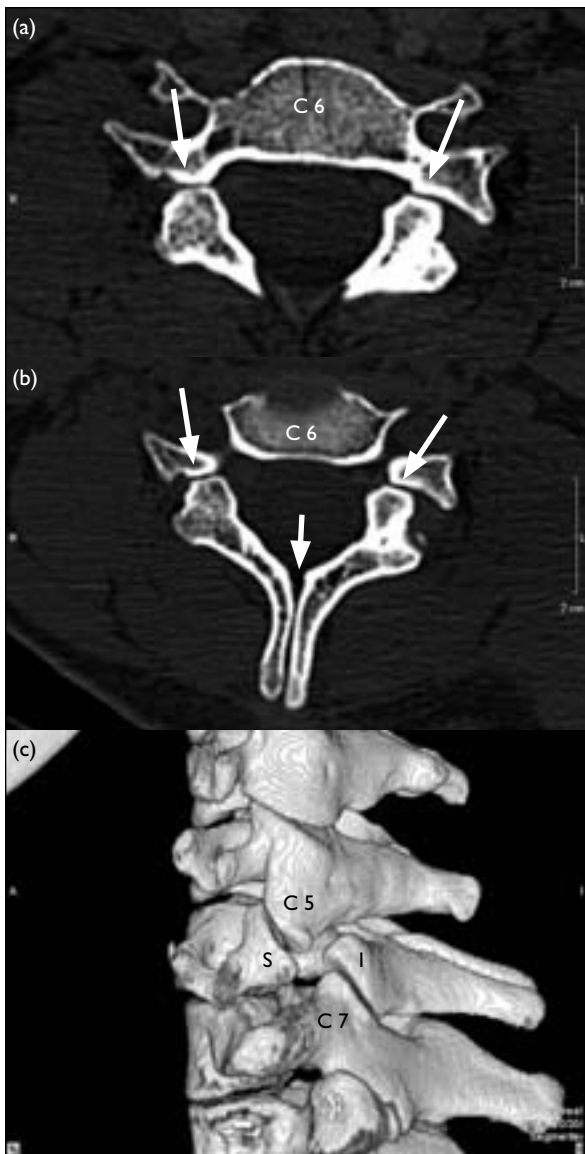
(a, b) Axial computed tomographic (CT) images of C6 vertebra revealed well-corticated cleft between bilateral C6 facets (long arrows) and spina bifida of C6 (short arrow). (c) Three-dimensional reconstructed CT image of the cervical spine showed a triangular configuration of the superior (S) and inferior (I) facet fragments on either side of the spondylolytic defect giving the 'bow tie' appearance. There was mild posterior displacement of the dorsal triangular pillar fragment and compensatory hyperplasia of the articular pillars at the levels above and below the defect
